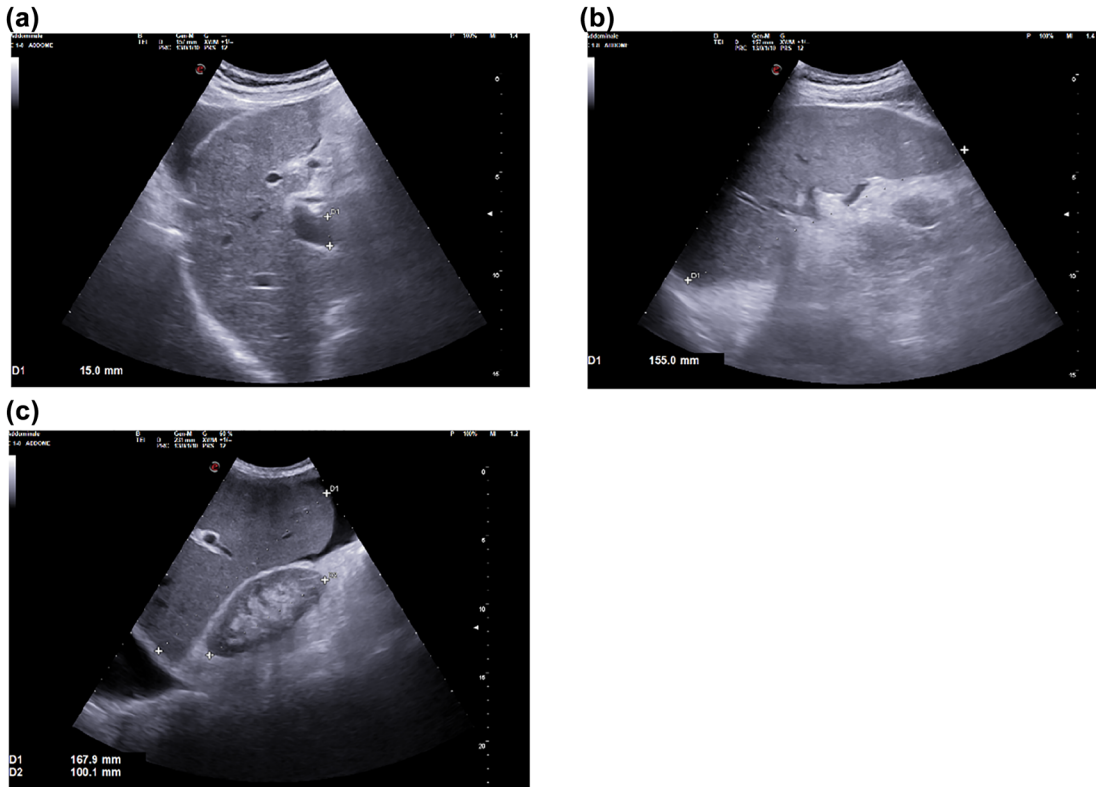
Ultrasound features of portal hypertension: dilated portal vein (PV) and ascites (a); splenomegaly (b); hepatomegaly with rounded angle, ascites, and pleural effusion in patient with HF and volume overload (c).
